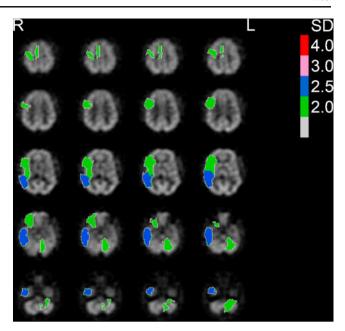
Quantified Tc-99m-ECD SPECT study shows a significant decrease of perfusion in the right temporal region, the right motor cortex, and the right inferior frontal region (*upper row*) associated with a hypoperfusion in the anterior and medial parts of the left cerebellar hemisphere including the dentate nucleus and middle cerebellar peduncle (*lower row*). Decreased perfusion in the right anterior temporal (-1.76 SD), the right cerebellar hemisphere (-1.32), the left inferior frontal (-1.77 SD), and the left motor cortex (-1.92 SD) is not indicated as it did not reach a significance level of >-2 SD
